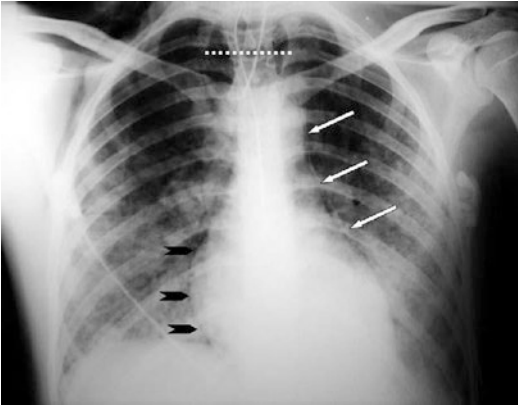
Penetrating tracheal injury secondary to intubation. Supine chest radiograph shows overdistention of the endotracheal cuff (*dashed line*). Furthermore, left pneumomediastinum (*arrows*), right heart contour outline (*arrowheads*), and bilateral pulmonary contusions are also evident (Reproduced with permission from Elsevier)
